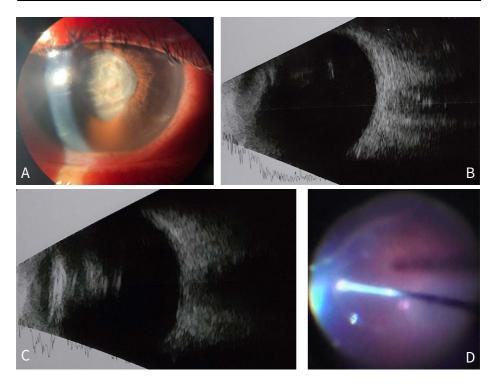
Clinical features of the right eye on presentation: (*A*) chemosis, mild corneal oedema, +4 flare, +4 cells, 1 mm hypopyon, and pupillary membrane on the slit lamp examination, as well as (*B*) vitreous opacities on B-scan ultrasonography. (*C*) B-scan ultrasonography of the right eye after 24 hours of emergency moxifloxacin intravitreal injection showing no improvement of vitreous opacities. (*D*) Pars plana vitrectomy after 24 hours of emergency moxifloxacin intravitreal injection showing no improvement of clinical features and B-scan ultrasonography.
